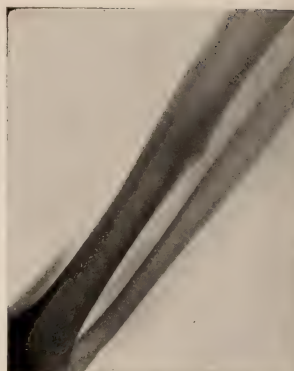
a—Case VI.—Pathol. No. 29019. Multiple infectious ossifying periostitis of femur and tibia. X-ray taken four months after that shown in Figure XII.
